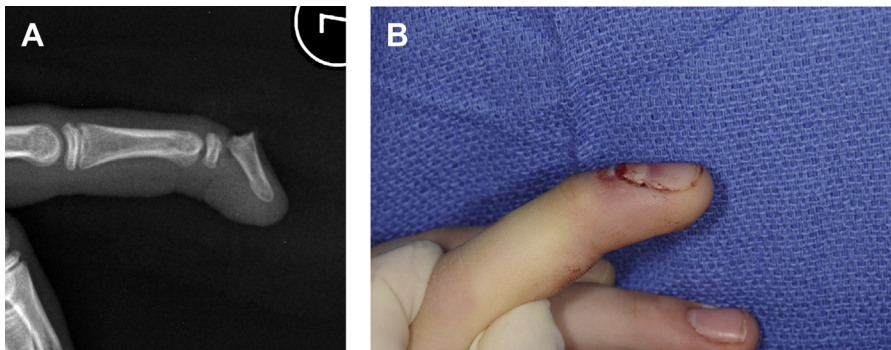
Seymour fracture. The Seymour fracture is an often missed open fracture of the distal phalanx best seen on lateral radiographs (A). Clinical appearance can be underwhelming and contributes to the underdiagnosis (B). (Courtesy of Shriners Hospital for Children Philadelphia.)
